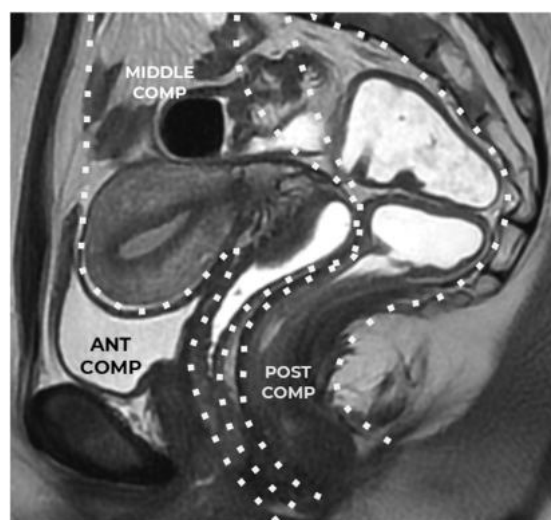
Pelvic compartments. Sagittal MRI T2WI shows multicompartmental anatomy of the pelvic floor.
